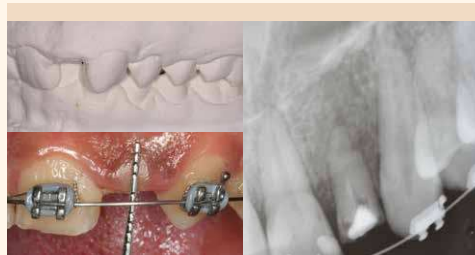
(A) Pre-treatment model showing deep overbite and cervical part of the lateral incisor. (B) Intraoral periapical radiograph shows the presence of maxillary left lateral incisor root piece with good interproximal bone levels. (C) Pocket depth of 6mm in the lateral incisor region indicating facial bone loss.
